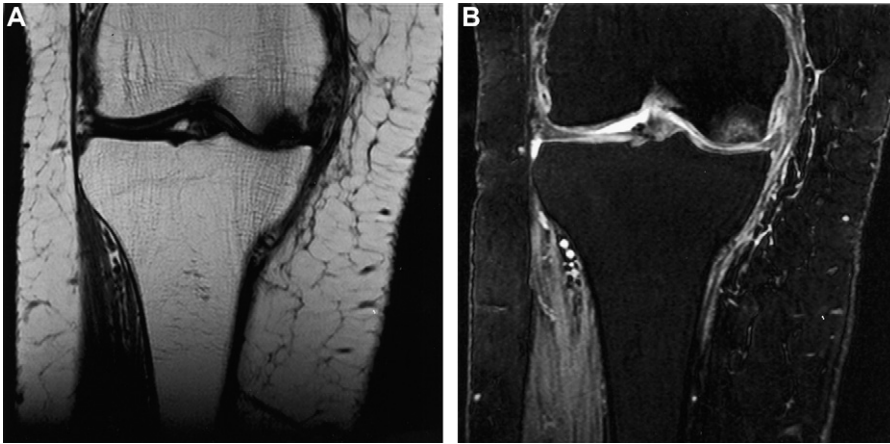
Coronal T1-weighted (A) and DESS (B) images demonstrate osteonecrosis of the medial femoral condyle.
